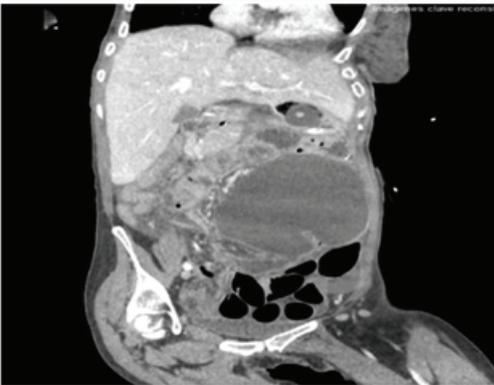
Sagittal plane on CT scan.
